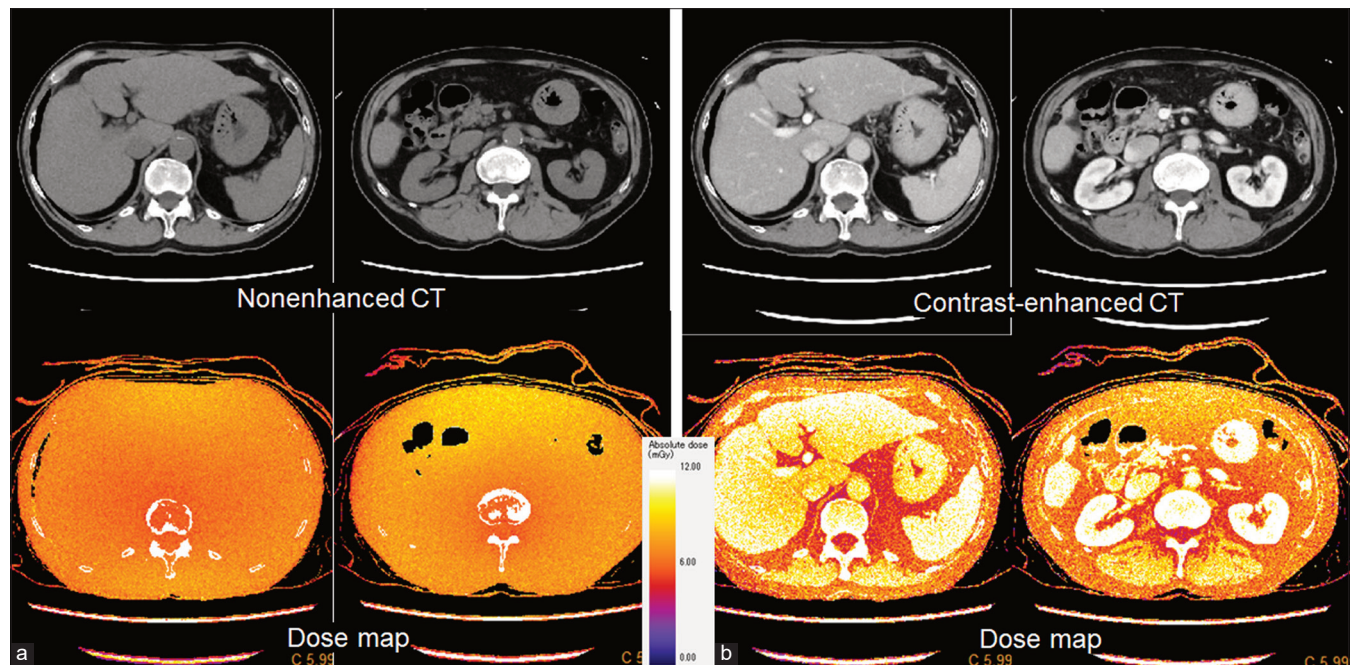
A 74-year-old man. The top row presents nonenhanced (a) and contrast-enhanced (b) CT images at the levels of the liver and kidneys. The bottom row displays the corresponding radiation dose maps at the same anatomical levels. The dose maps indicate higher radiation doses with increasing whiteness. (a) In NECT, bone exhibited the highest dose, whereas the liver and kidneys showed comparable dose levels. (b) In contrast, in CECT, the doses in the kidneys were increased compared with that in the liver, reflecting higher contrast enhancement in the kidneys. In addition, in the liver, higher doses were observed near the surface, with a gradual decrease toward internal regions, as indicated by the color gradient.
